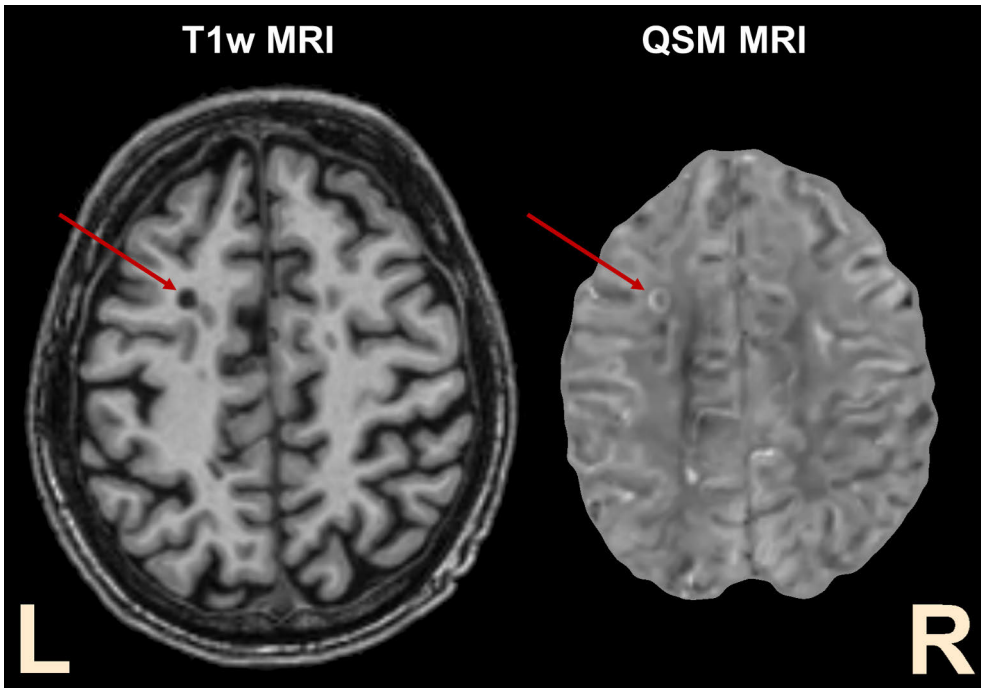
Visual demonstration of the axial T1 MR image (left) and respective QSM MR image (right). Red arrow points to a chronic T1 lesion showing bright paramagnetic rim in QSM MRI. Abbreviations: MRI = magnetic resonance imaging; QSM = quantitative susceptibility mapping.
